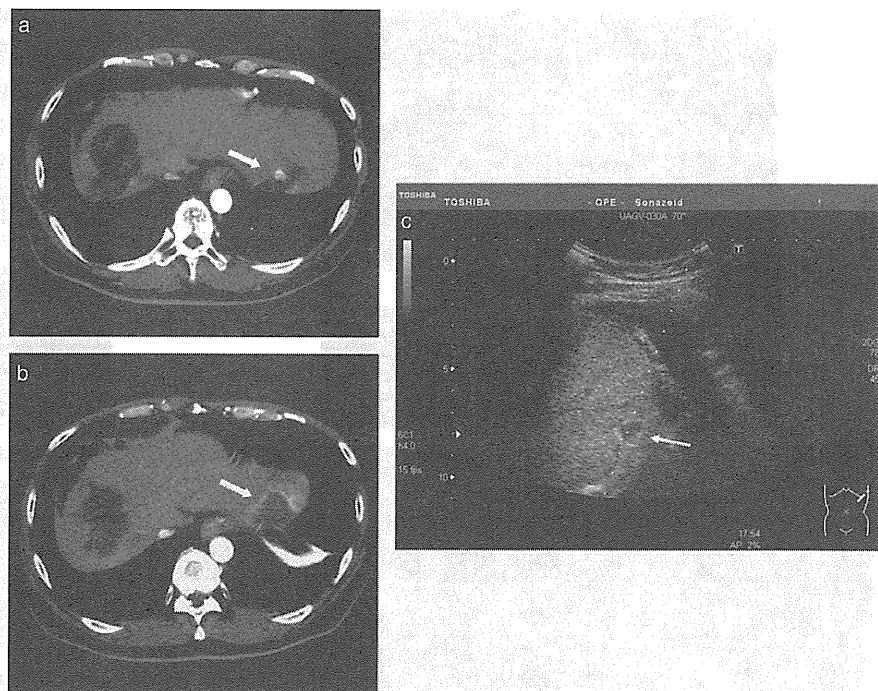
(a) A 52-year-old man with hepatocellular carcinoma. Computed tomography revealed a nodule at the left lateral lobe. (b) This lesion was clearly detected as an enhanced defect in the Kupffer imaging phase. Artificial left pleural effusion was used. (c) The nodule was sufficiently ablated.
